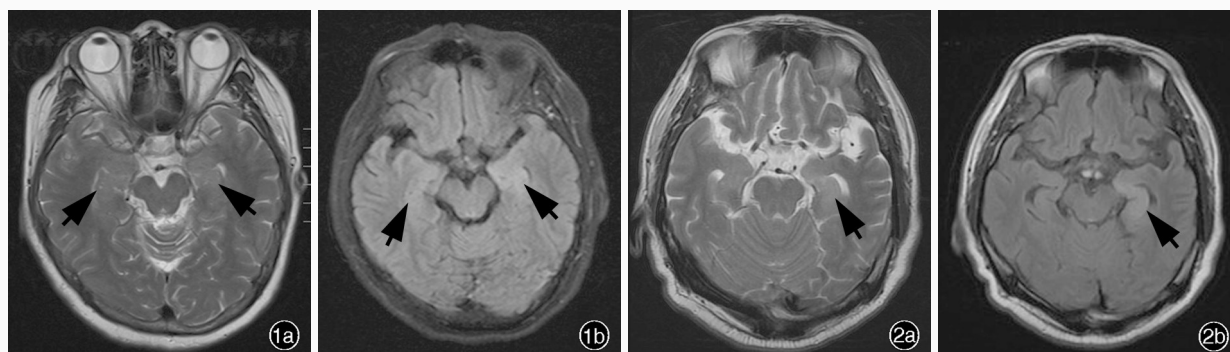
女性患者,60岁。临床诊断为抗 LG11 抗体相关边缘性脑炎。头部 MRI 检查所见 1a 横断面 T₂WI 显示左侧颞叶海马和海马旁回、右侧颞极稍高信号影(箭头所示) 1b 横断面 FLAIR 成像病变呈高信号(箭头所示) 图2 男性患者,56岁。临床诊断为抗 LG11 抗体相关边缘性脑炎。头部 MRI 检查所见 2a 横断面 T₂WI 显示左侧海马略高信号影(箭头所示) 2b 横断面 FLAIR 成像显示病变呈高信号(箭头所示)
